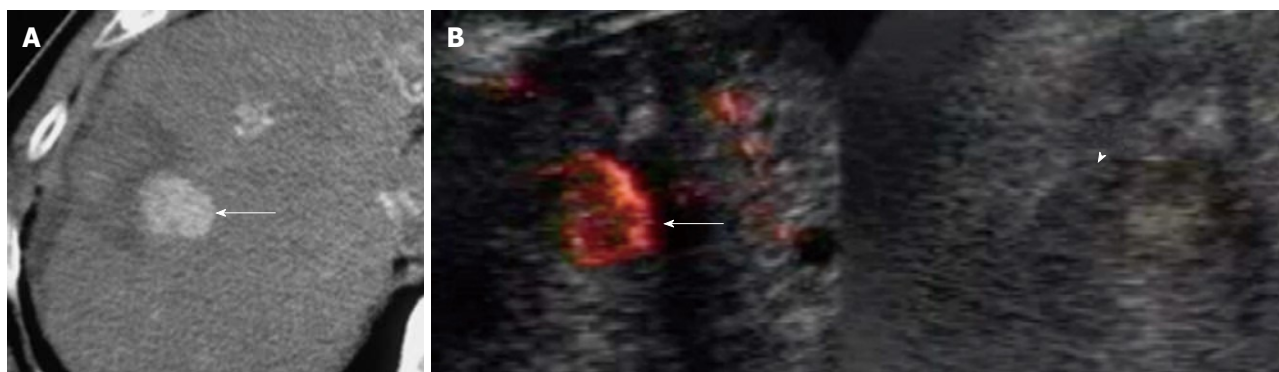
A 71-year-old man with 2.0 cm local tumor progression of hepatocellular carcinoma after radiofrequency ablation therapy in segment 8 of the liver. A: Early-phase dynamic computed tomography (CT) scan shows outgrowth pattern of locally progressive hepatocellular carcinoma (HCC) (arrow). The lesion borders an unenhanced area, which was previously treated; B: Left: Contrast harmonic Doppler ultrasound (US) using Levovist shows enhancement of local tumor progression of HCC (arrow). Therefore, an enhanced lesion can be identified as a target for the insertion of a single RF electrode; Right: B-mode US shows a HCC nodule demonstrated as a low echoic lesion with an unclear border (arrowhead).
